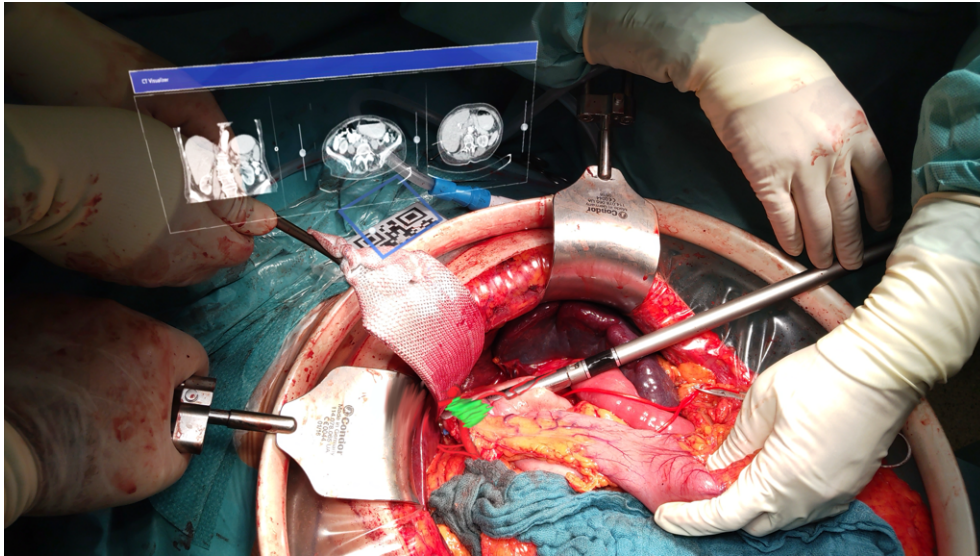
A snapshot showing manual placement of scaled CT slices near the operation field done by the surgeon during the operation for a closer and continuous observation.
